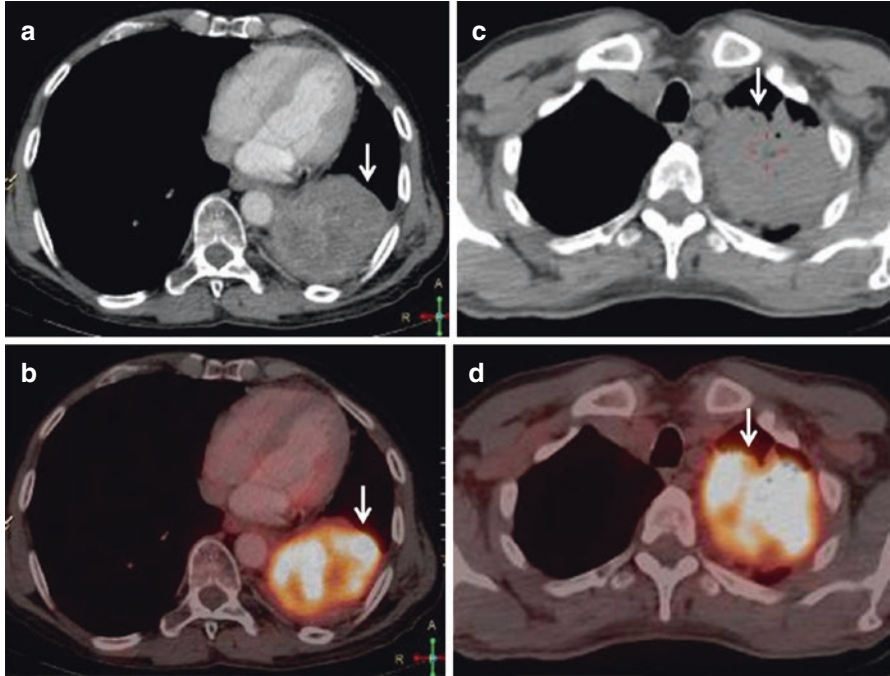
Axial CT and fusion PET/CT (arrows in a, b) images in a patient of non-small cell lung cancer show a FDG-avid mass lesion. Axial CT and fusion PET/CT (arrows in c, d) images show pulmonary tuberculosis presenting as a mass-like lesion
